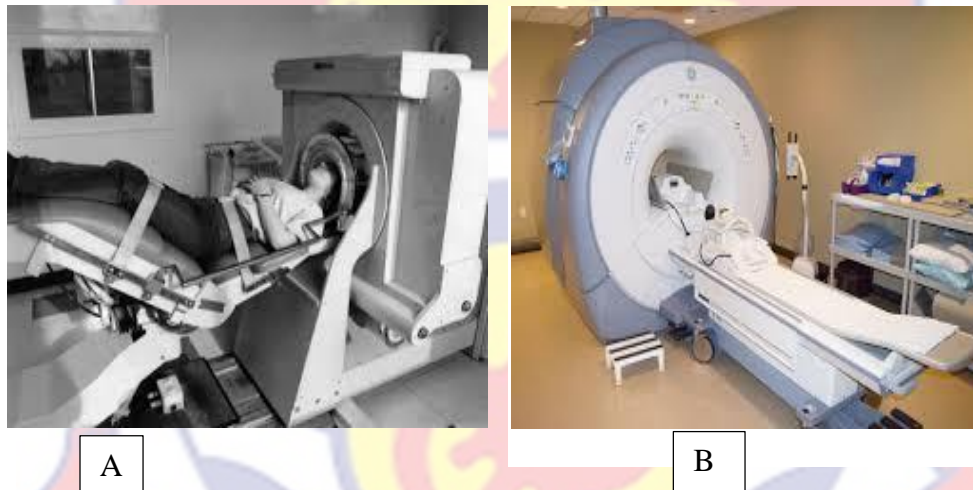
Old (A) and modern (B) CT scanner systems. Source: isct.org, 2018
